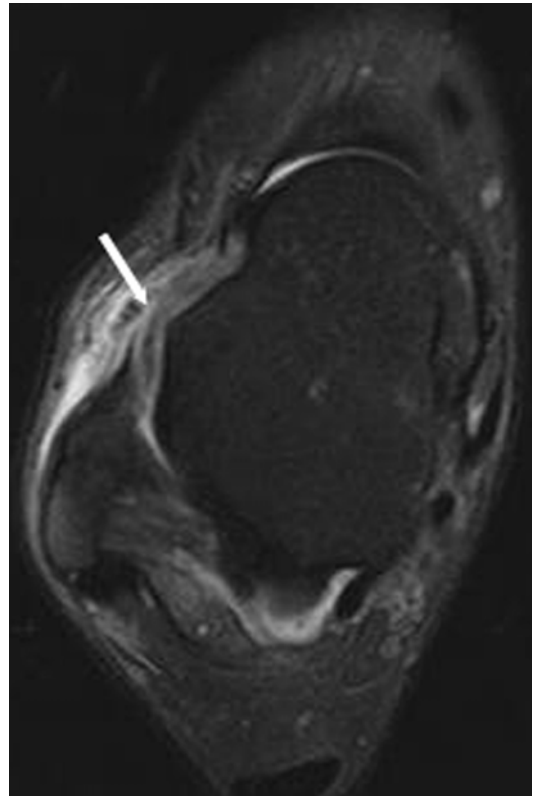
Anterior talofibular ligament attachment tear (*arrow*) on axial FS T2-weighted image. We cannot see the ligament attachment to the talus, and edema in the capsule and extensor retinaculum is prominent
